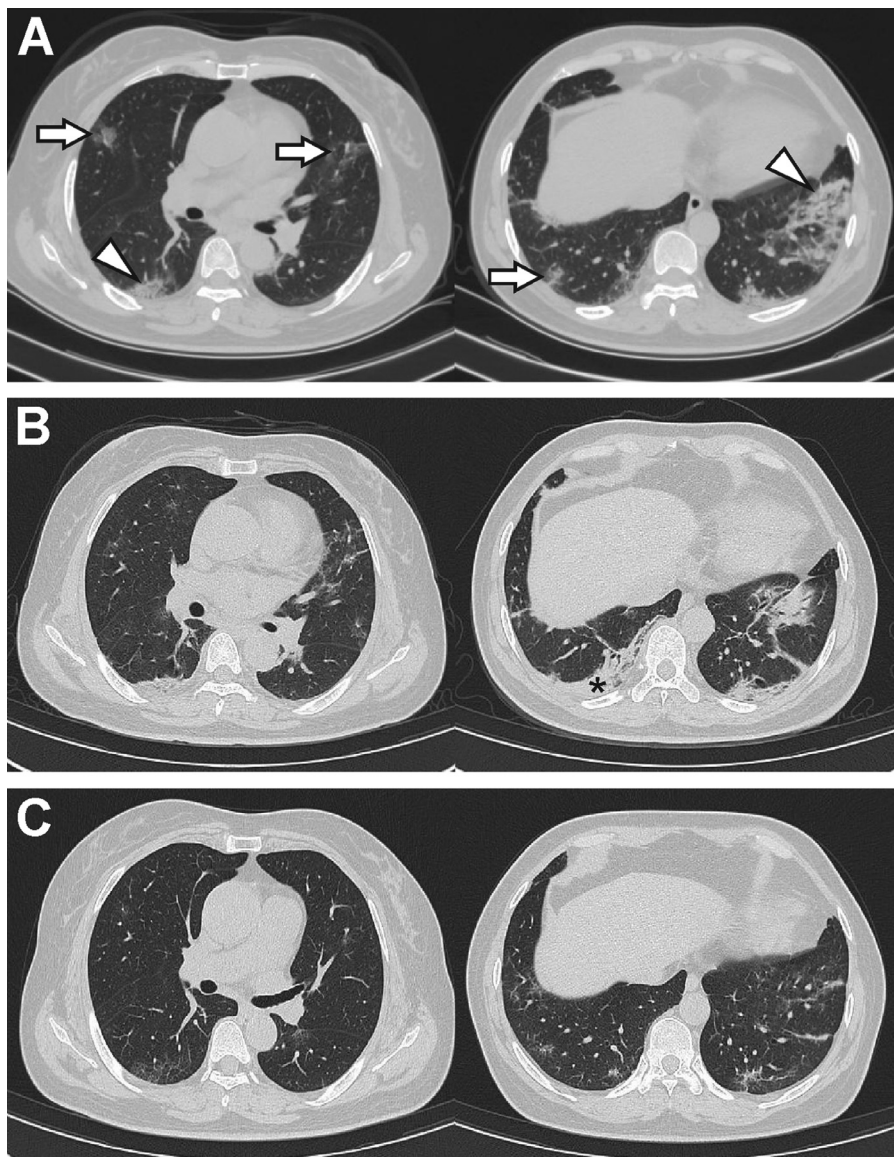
Figure (A) Chest computed tomography (CT) showed multifocal ill-defined nodular ground-glass opacities and patchy consolidations lesions distributed in the middle-lateral zone and subpleural regions. (B) Chest CT showed decreased extent and intensity of the lesions and irregular consolidation in the subpleural regions of the right lower lung. (C) Chest CT showed significantly decreased lesions.
